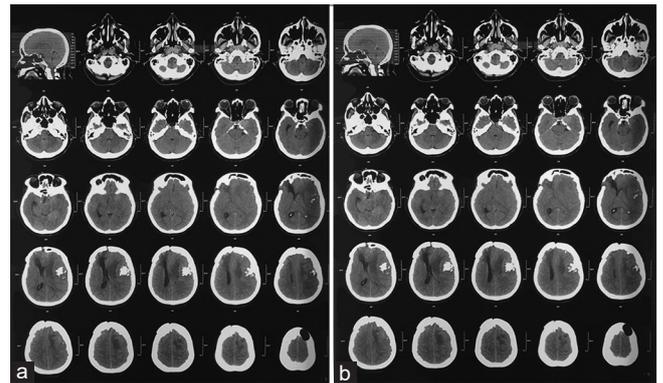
Non-contrast computerized tomography (CT) scan (a), CT scan by contrast (b), revealed multiple meningiomas, peritumoral edema, midline shift, cerebral edema were found
